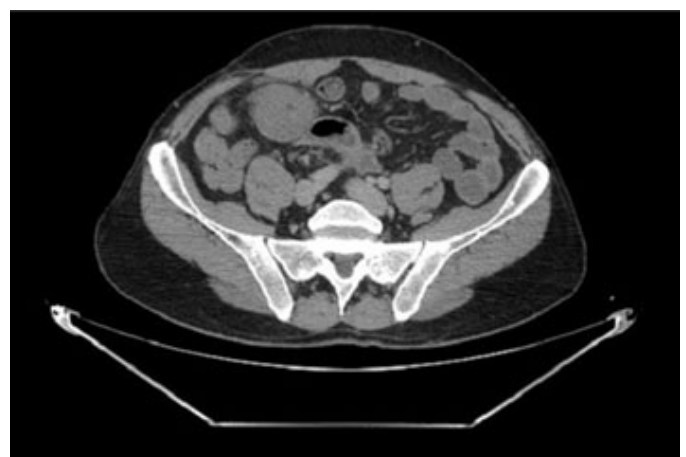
Axial abdominal computed tomography (CT) scan at one year post-surgery, revealed a nodular right-sided mesenteric mass with soft-tissue density.
